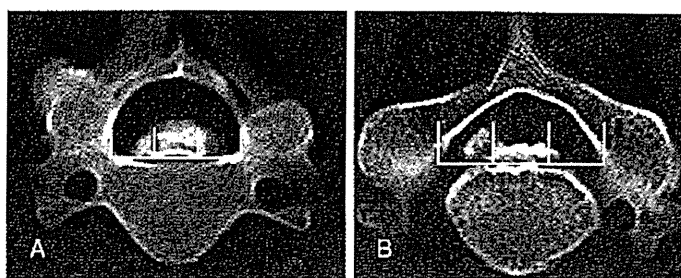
Classification of the axial ossification pattern on CT examination.
